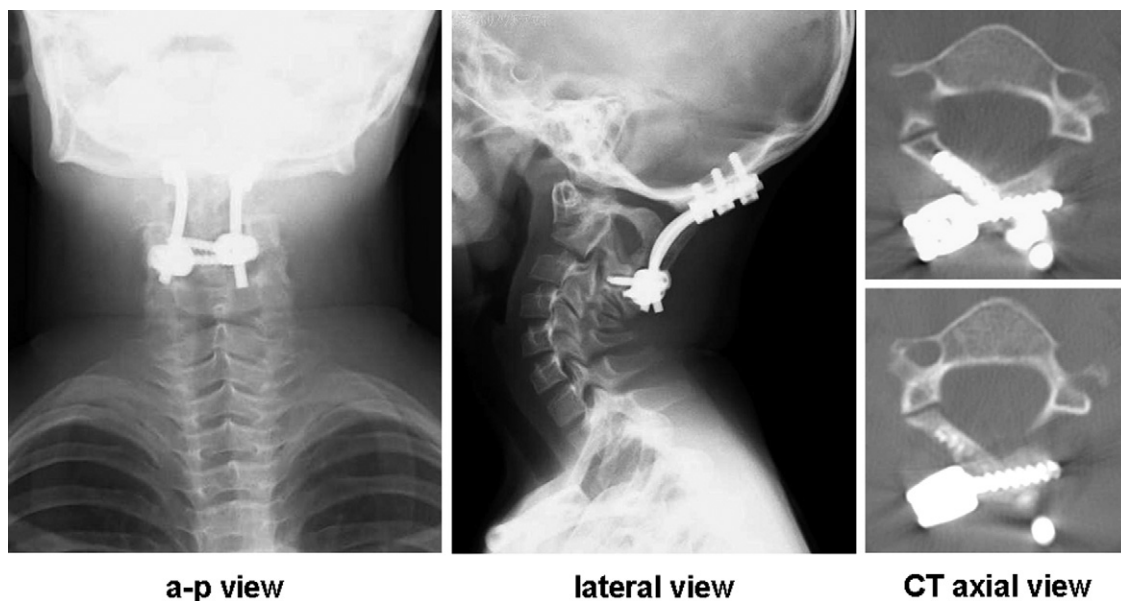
Postoperative X-ray (obtained 1 year 3 months after surgery) and CT scan (obtained 4 weeks after surgery) in case 1. Alignment of the cervical spine had improved, and the positions of the bilateral C2 laminar screws were correct. (a-p, anteroposterior.)
